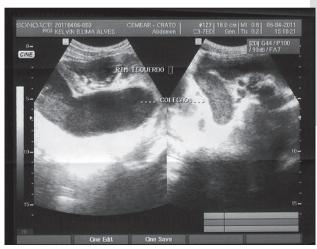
Ultrasonographic image of left kidney and ureter
